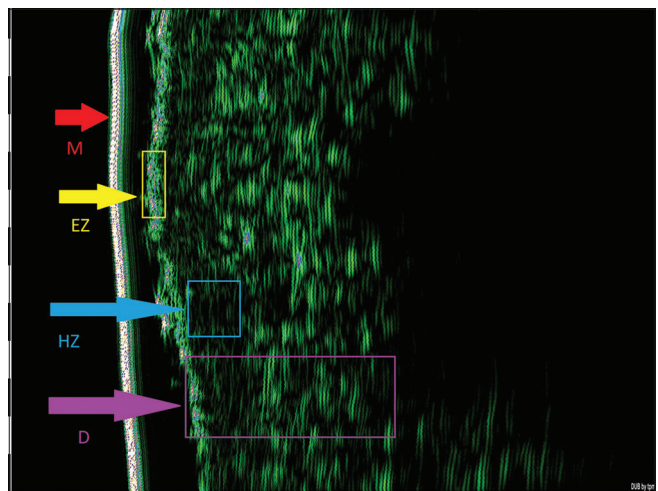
Infiltration in the dermis. Characteristic pattern of the hypoechoogenic shadow (hypoechoogenic zone, HZ) (sonographic imagine, 22.5 MHz); M—membrane, E—entry zone, HZ—hypoechoogenic zone, D—dermis.
